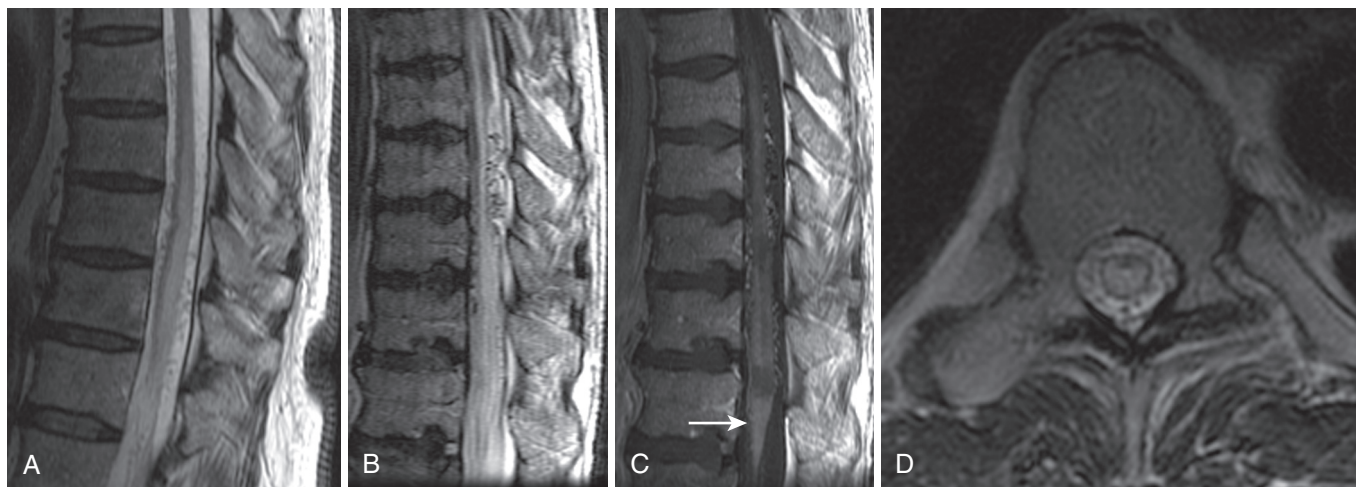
Dural arteriovenous fistulae. T2 sagittal MRI images in two patients, (A) and (B), both demonstrate enlargement of the conus with multisegmental T2 hyperintensity. Postgadolinium T1 sagittal MRI (C), same patient as (B) shows intravascular enhancement in the enlarged perimedullary veins and patchy parenchymal enhancement in the conus (arrow). Axial T2 image through the lower thoracic cord (D) demonstrates increased T2 signal throughout the substance of the cord, with a dark border of diminished T2 signal at the periphery of the cord. (From Morris JM. Imaging of dural arteriovenous fistula. *Radiol Clin North Am.* 2012;50:823-839.)
